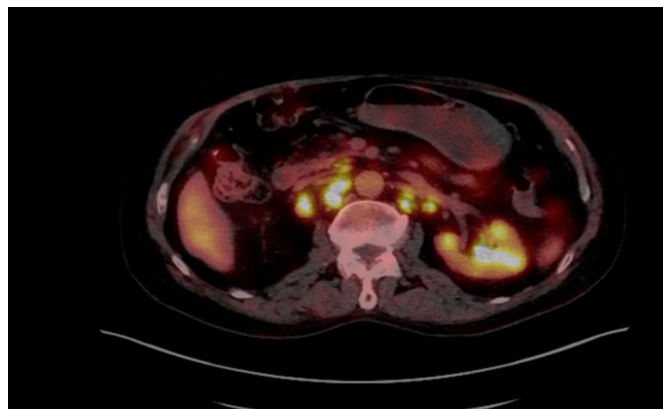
Positron emission tomography-computed tomography (PET-CT)
